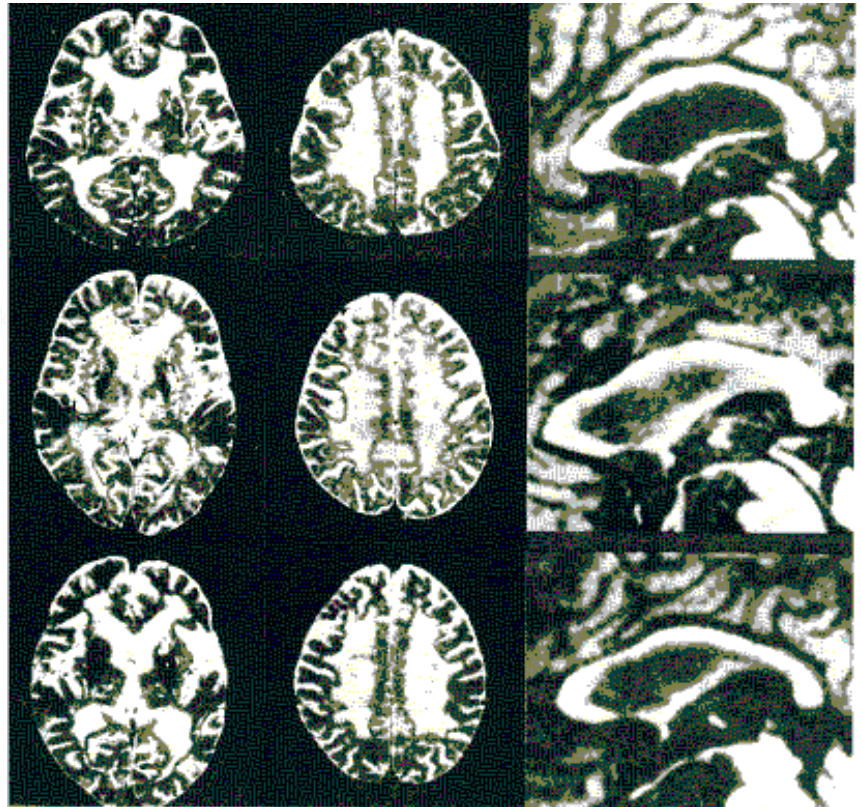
Examples of high-intensity lesions on T2-weighted magnetic resonance (MR) images (TR 3000 ms/TE 80 ms) (left and middle columns) and corpus callosum atrophy on T1-weighted images (TR 400 ms/TE 20 ms) (right column).³ Upper row shows mild atrophy of the corpus callosum (no dementia, total intelligence quotient (IQ) = 107; middle row shows moderate atrophy (mild dementia, total IQ = 81); lower row shows severe atrophy (moderate dementia, total IQ < 60).
